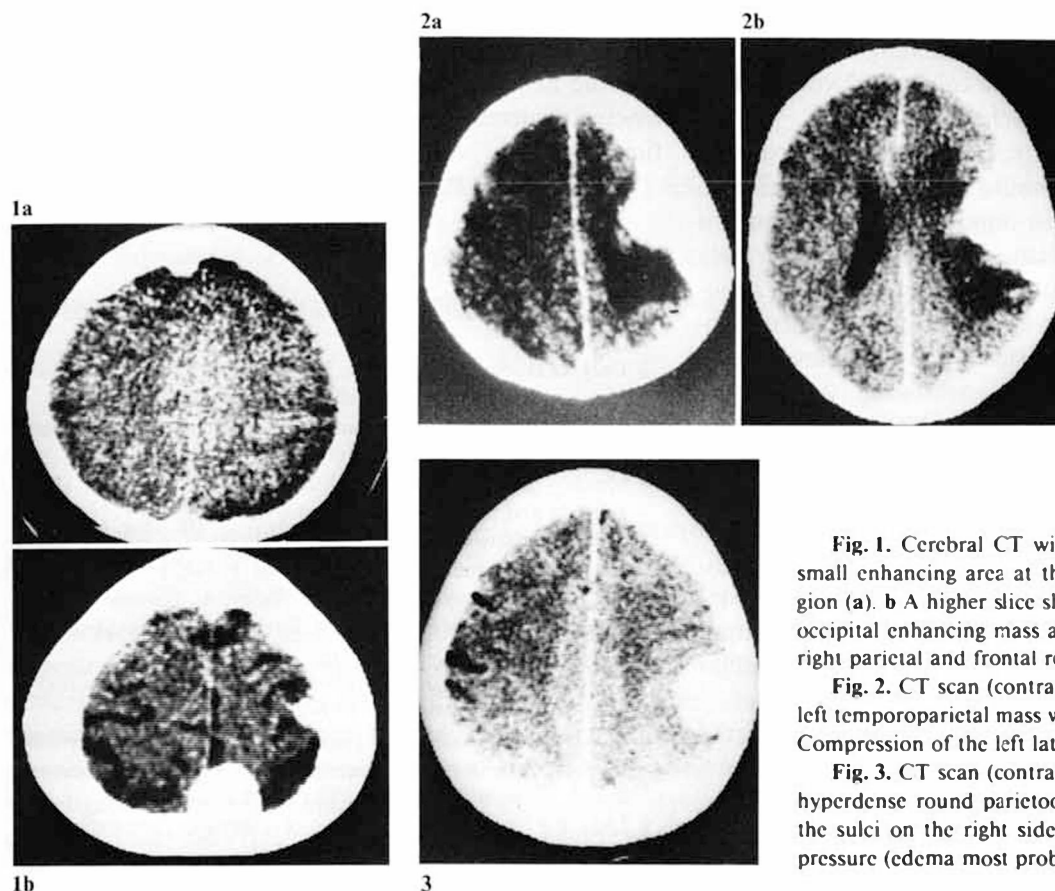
Cerebral CT with contrast media showing a small enhancing area at the left parasagittal frontal region (a). b A higher slice shows a large right parasagittal occipital enhancing mass and two smaller masses at the right parietal and frontal regions.
